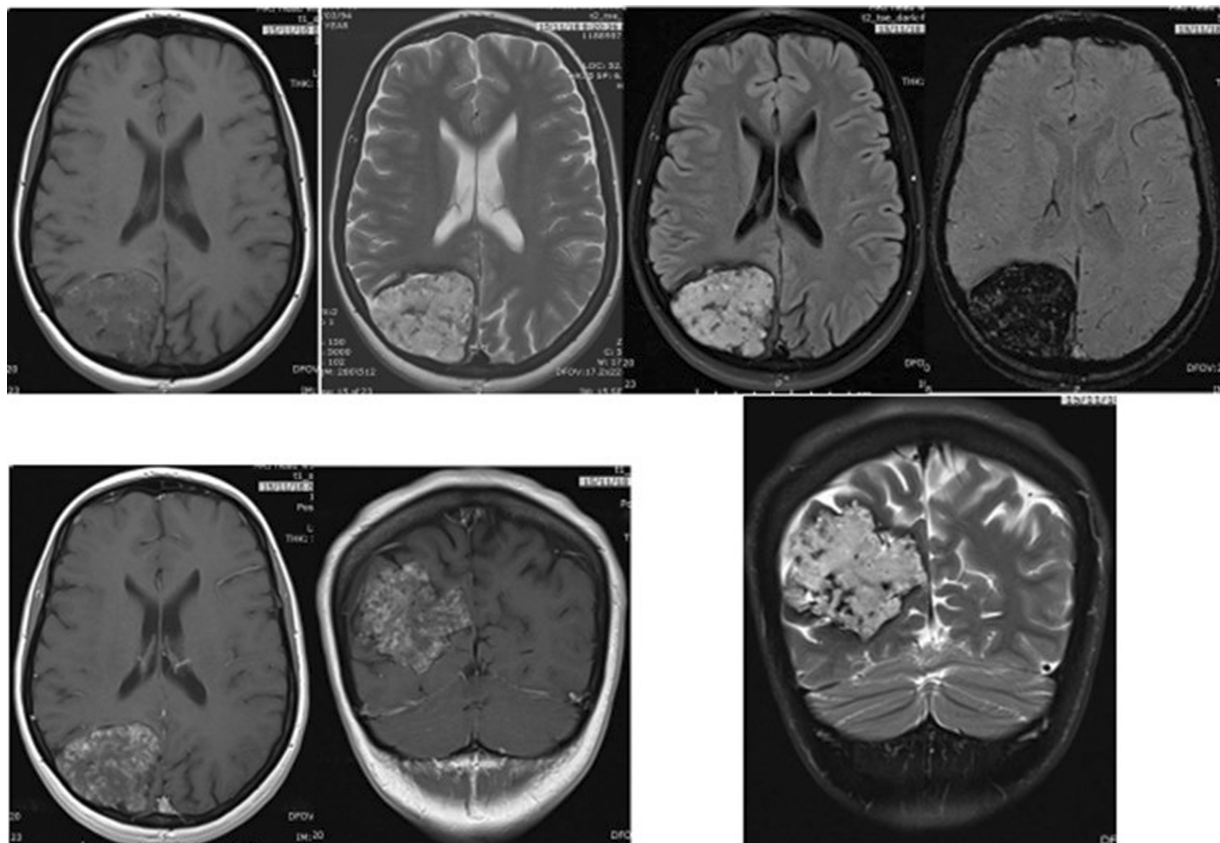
Brain magnetic resonance imaging (MRI) showing right occipital dura-based mass lesion. T2 and fluid-attenuated inversion recovery-weighted images displaying intermediate to high signal. Blooming dark low signal intensity on susceptibility weighted images. There is no obvious dura tail, and from the previous computed tomography scan, there is no hyperostosis, suggested differential diagnosis of atypical meningioma, or hemangiopericytoma.
